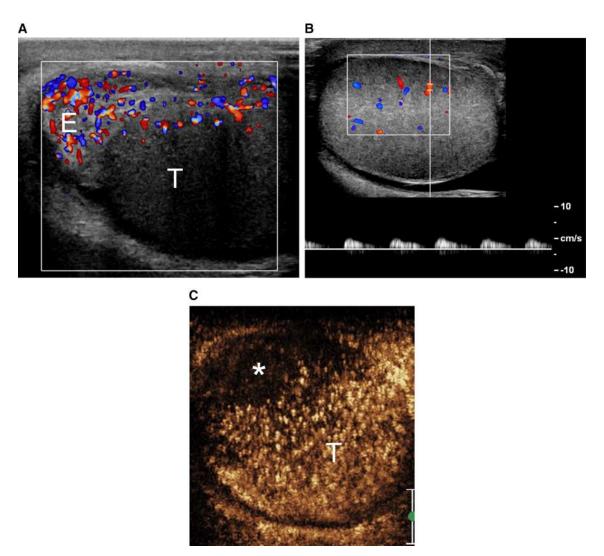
Post-inflammatory testicular ischemia in a patient with severe epididymo-orchitis. A Color Doppler ultrasonography shows hypoechoic, hypovascular testis (T) and enlarged, hypervascular epididymis (E). B Spectral Doppler
